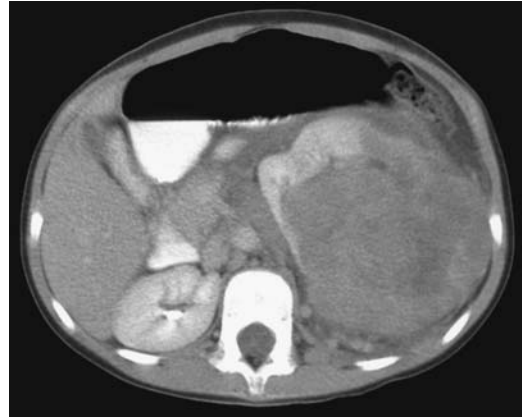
Anaplastic Wilms' tumor in a 6-year-old with a palpable abdominal tumor. Computed tomography identifies a left renal tumor deviating the kidney anterior and medial. A claw sign suggests the diagnosis. Adenopathy is also present. Other studies detected pulmonary metastases. (Courtesy of Luann Teschmacher, M.D., University of Rochester.)
